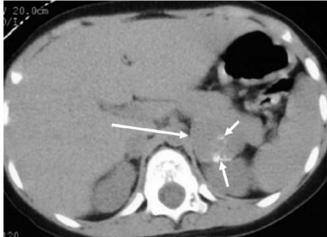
A 2-year-old female with a neuroblastoma. Unenhanced CT image demonstrates a 2.5-cm soft tissue mass (*long arrow*), which contains a small amount of calcification (*short arrows*) in the left adrenal gland. A neuroblastoma was confirmed pathologically
